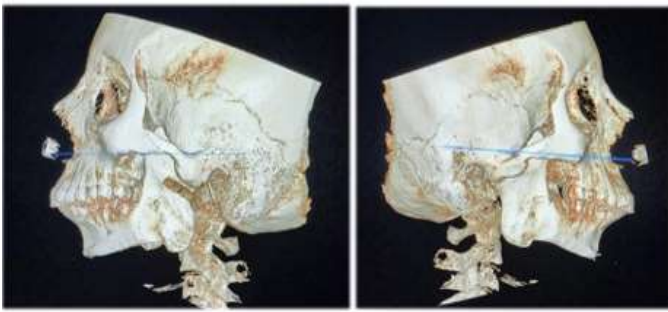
CBCT View of Right and Left Sides Showing Bilateral TMJ Ankylosis.
